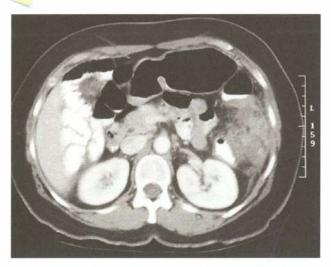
CT scan showing pericolic abscess on the left paracolic space
